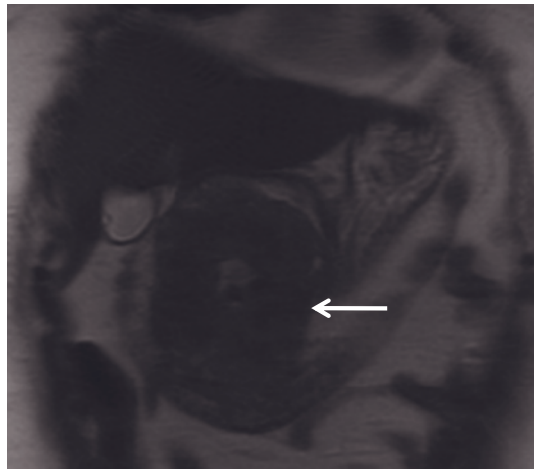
Gastric adenocarcinoma, body. Coronal T2-weighted SS-ETSE (*a*), coronal precontrast SGE (*b*), transverse immediate postgadolinium SGE (*c*), and transverse 2-min postgadolinium fat-suppressed SGE (*d*) images. A circumferential low-signal-intensity mass is demonstrated in the body of the stomach. The high-signal-intensity fluid contents of the stomach permit good delineation of the low-signal-intensity mass on the T2-weighted SS-ETSE image (arrow, *a*). The mass is isointense to the stomach wall on the precontrast T1-weighted image (*b*). On the immediate postgadolinium image, the tumor (arrows, *c*) shows mild
